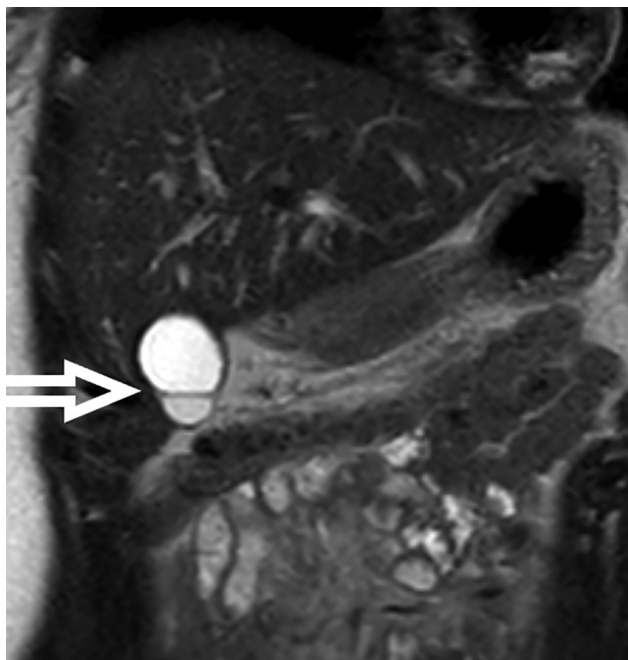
A Phrygian cap on MRI. MRI indicates magnetic resonance imaging.
